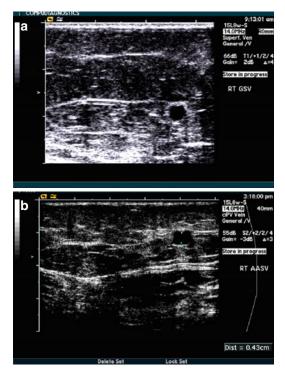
The transverse image of the target vein is placed at the center of the ultrasound screen (a, *above*) and the needle is introduced in direct line with the target (b, *below*)
